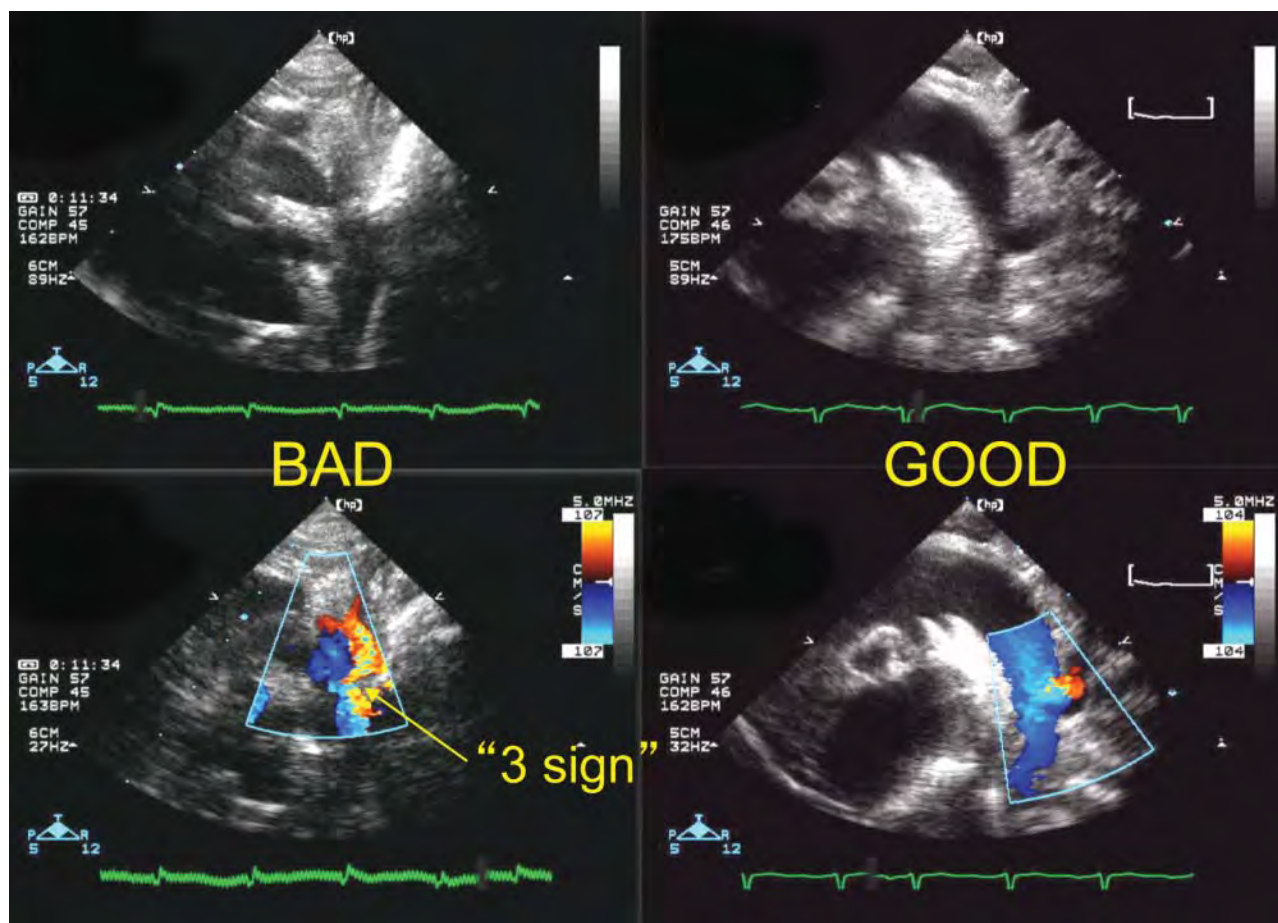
It is essential to evaluate the retrograde aortic arch prior to considering Hybrid palliation, which is particularly important in patients with aortic atresia. Echocardiography is the initial diagnostic technique of choice to image retrograde aortic arch (RAA), with the suprasternal views providing the best images. In patients with a concern for retrograde aortic arch obstruction (RAAO), the RAA is often “pinched in” at its ductal insertion (3-sign) with flow acceleration across the RAA, as shown on the left-hand image (unsuitable for Hybrid palliation). On the right-hand image, the RAA has a wider origin without being pulled in and less flow acceleration (suitable for Hybrid palliation). Where echocardiography does not clearly delineate the RAA, other diagnostic methods such as CT scanning should be considered.
